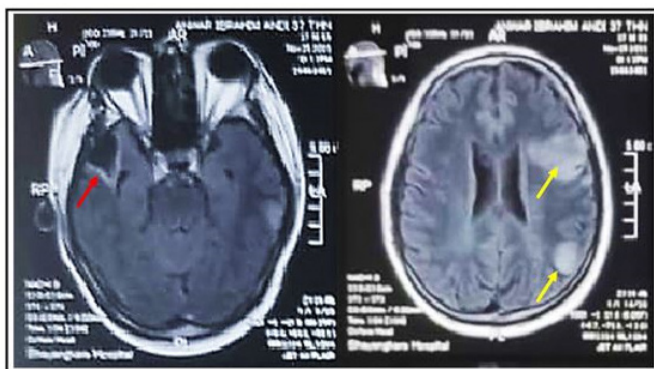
Non-contrast MRI of the patient’s head shows chronic infarction in the right temporal area (red arrow), and multiple subacute infarctions in the left temporoparietal region (yellow arrow).
